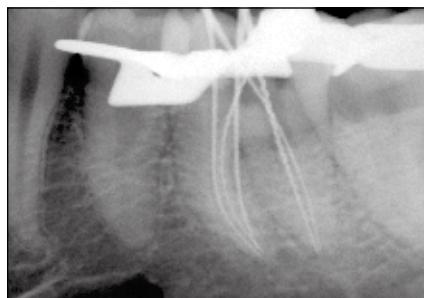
Radiograph taken to determine working length.
